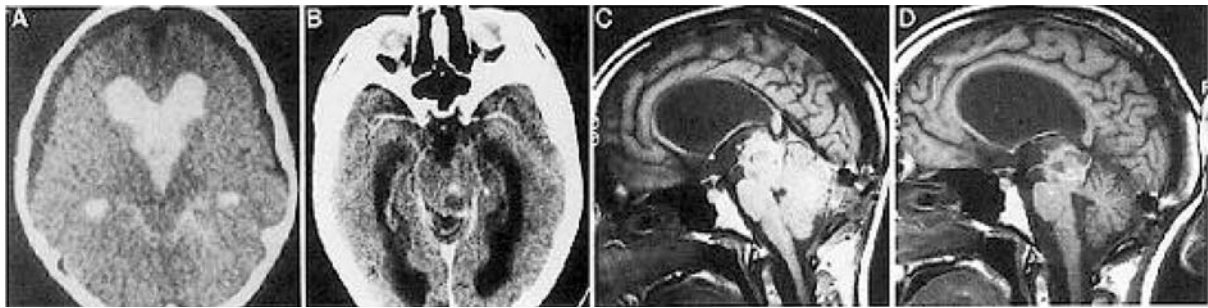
Neuroimaging in Case 1, a 22-year-old woman who initially presented at 8 years of age with longstanding macrocephaly as well as headaches and memory loss. Tumor progression was documented both clinically and radiographically in this patient. A: Metrizamide computerized tomography (CT)-cisternogram obtained in 1979, several days after performance of a third ventriculostomy, showing profound ventriculomegaly without convincing evidence of a tectal tumor. A ventriculoperitoneal shunt was required several months later because of worsening ventriculomegaly. B: A CT scan obtained in 1985 after the onset of Parinaud's syndrome showing a mixed-density tectal lesion. C: Sagittal T₁-weighted magnetic resonance image showing an exophytic tectal mass with extension into the midbrain tegmentum. D: Magnetic resonance image obtained 4 years after biopsy, cyst drainage, and external radiotherapy, showing a decrease in lesion size; the patient's Parinaud's syndrome had resolved.
